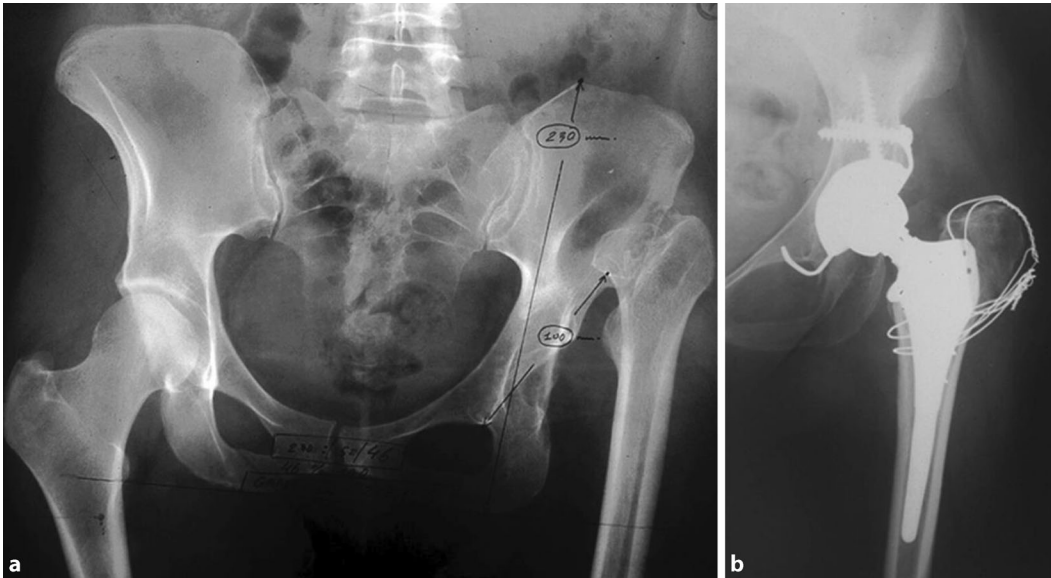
◀ Crowe IV DDH with greater trochanter osteotomy. Frontal X-ray image of the pelvis and the hip showing Crowe IV DDH case of the left hip (a) and the post-operative view (b) with the custom stem combined to greater trochanter osteotomy
